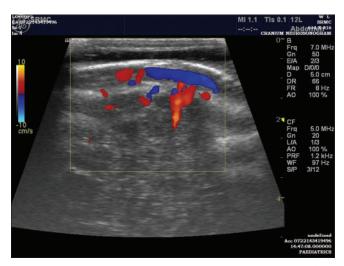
Ultrasound Sonography showing subaponeurotic fluid collection in case 2.
